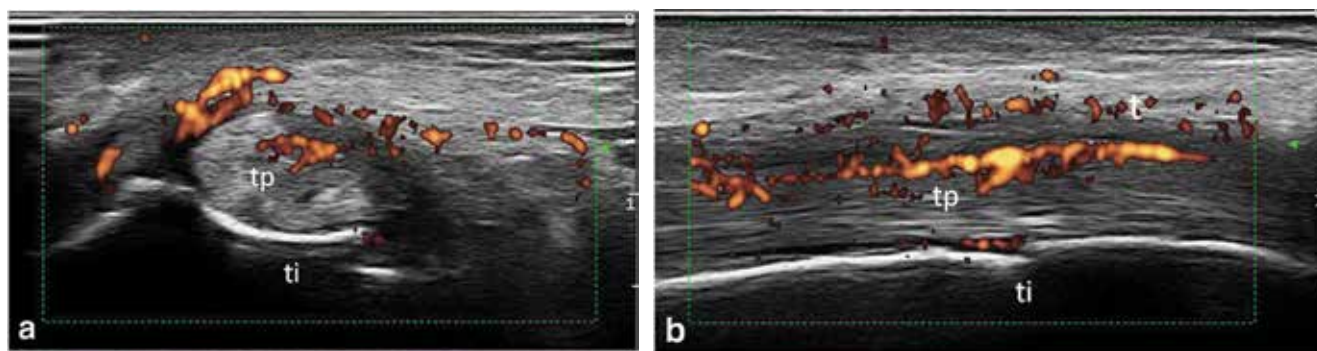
Representative power Doppler ultrasound images showing an active tenosynovitis of the tibialis posterior tendon (tp). Images were acquired in transverse (a) and longitudinal (b) scans. ti = tibia
